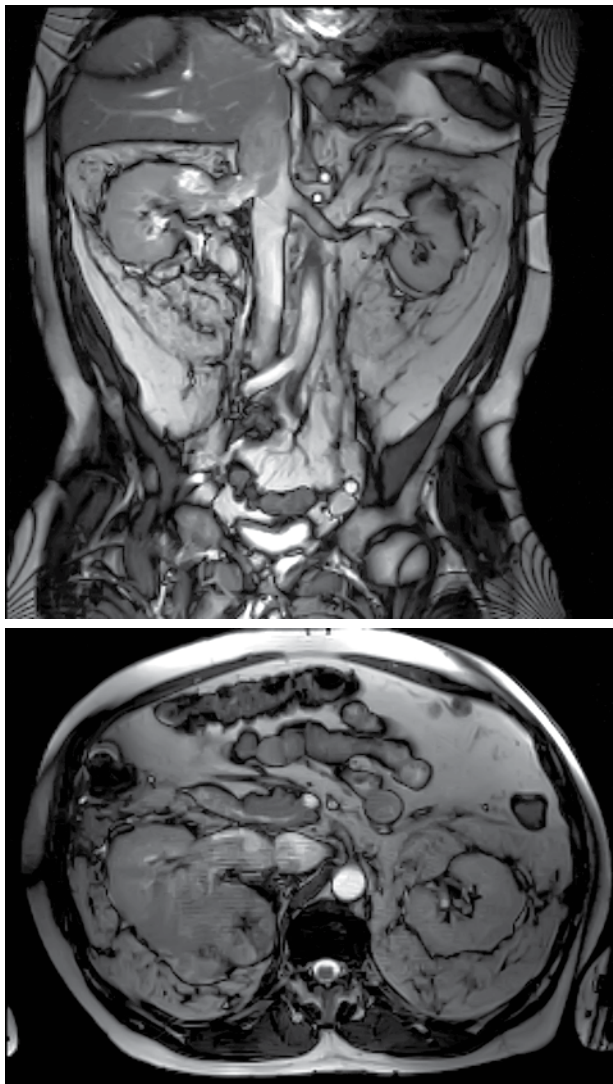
MRI images of a tumour extending from the upper pole of the right kidney into the inferior *vena cava*. The tumour extends above the level of the diaphragm (level IV).
